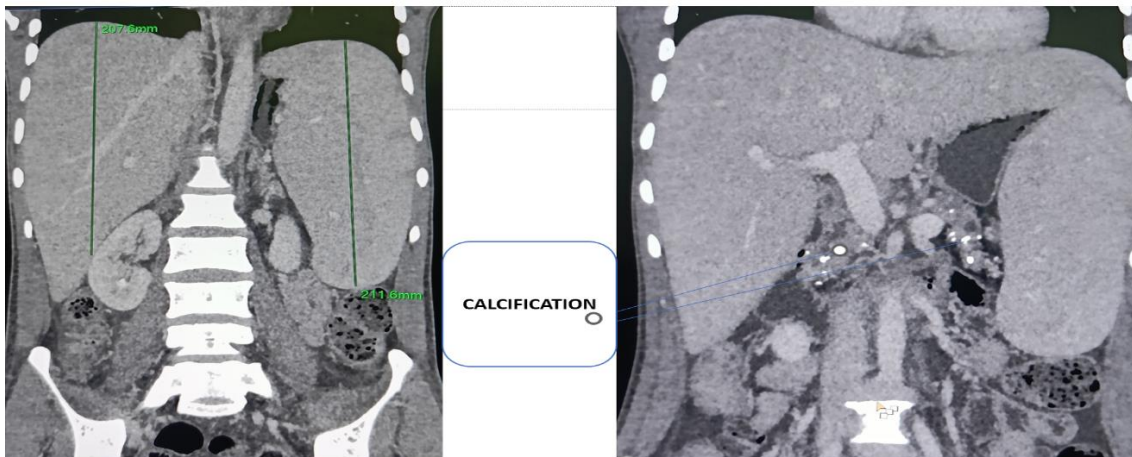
CT Abdomen showing hepatosplenomegaly and pancreatic calcification.
